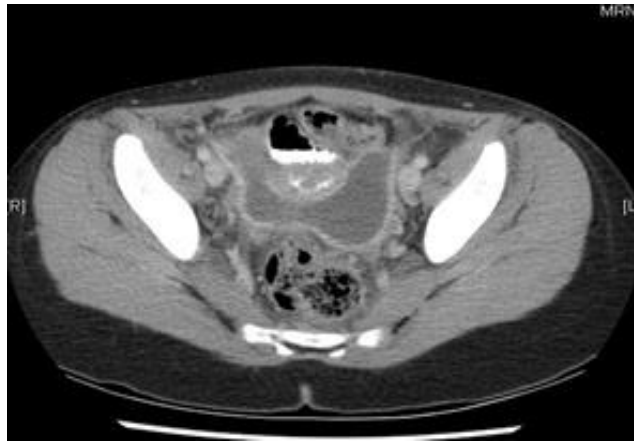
A computed tomography scan demonstrating abscesses in the pouch of Douglas.
